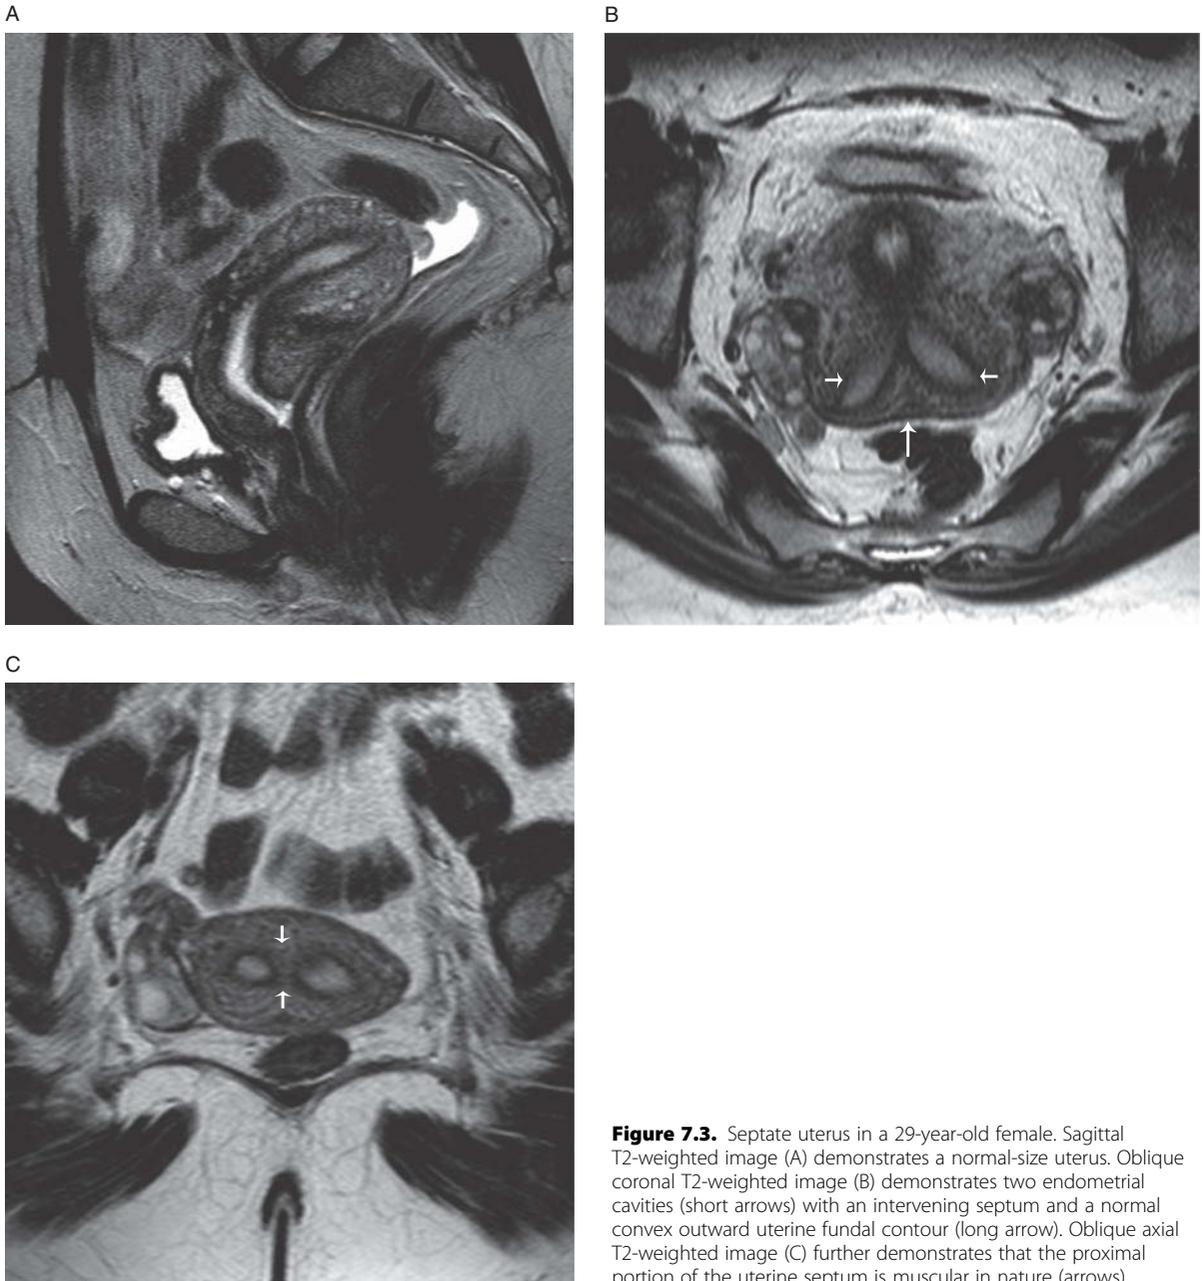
Septate uterus in a 29-year-old female. Sagittal T2-weighted image (A) demonstrates a normal-size uterus. Oblique coronal T2-weighted image (B) demonstrates two endometrial cavities (short arrows) with an intervening septum and a normal convex outward uterine fundal contour (long arrow). Oblique axial T2-weighted image (C) further demonstrates that the proximal portion of the uterine septum is muscular in nature (arrows).
